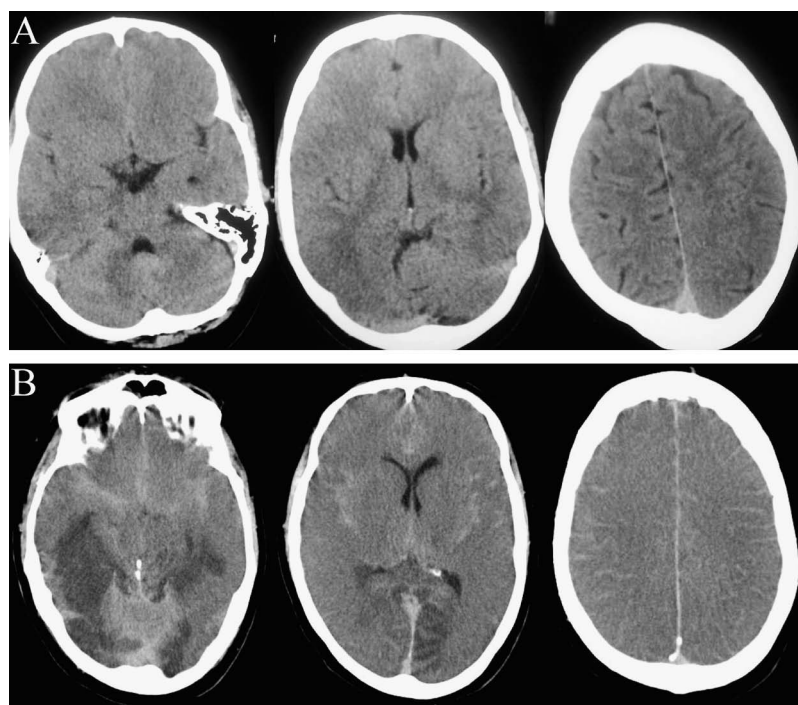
A: Cranial CT without contrast on the day of admission. B: Cranial CT without contrast on the third day of evolution.
